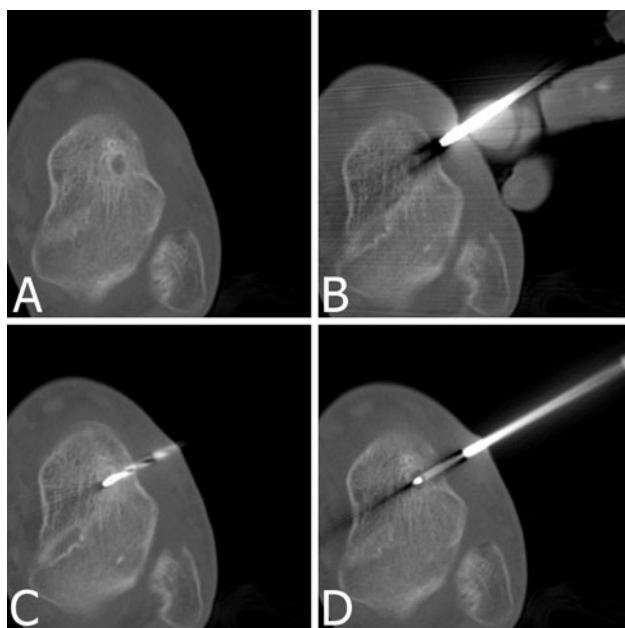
RFA for a 6-mm-diameter OO of the talus in a 16-year-old boy is shown. CT scans show (A) the medullary nidus with surrounding sclerosis, (B) driving the coaxial guide toward the nidus, (C) drilling the track up to the nidus, and (D) the radiofrequency needle in the nidus.
